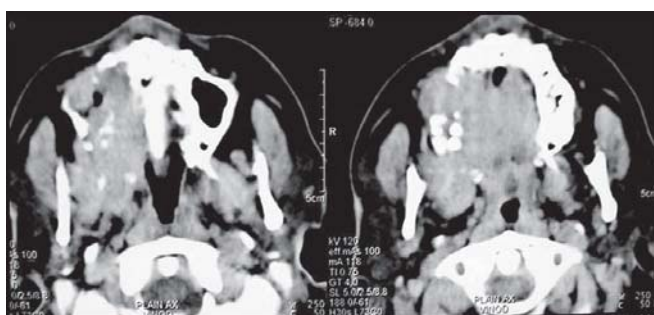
Axial CT show an isodense to hypodense heterogenous enhancing growth with destruction (Ref. Fig. 18.8B)
